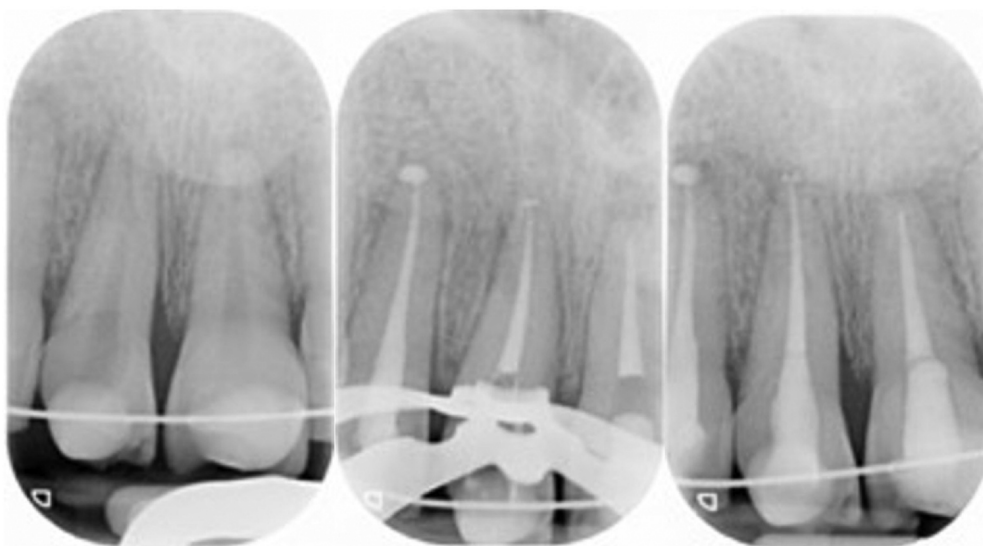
Radiographs after trauma and during endodontic treatment.
